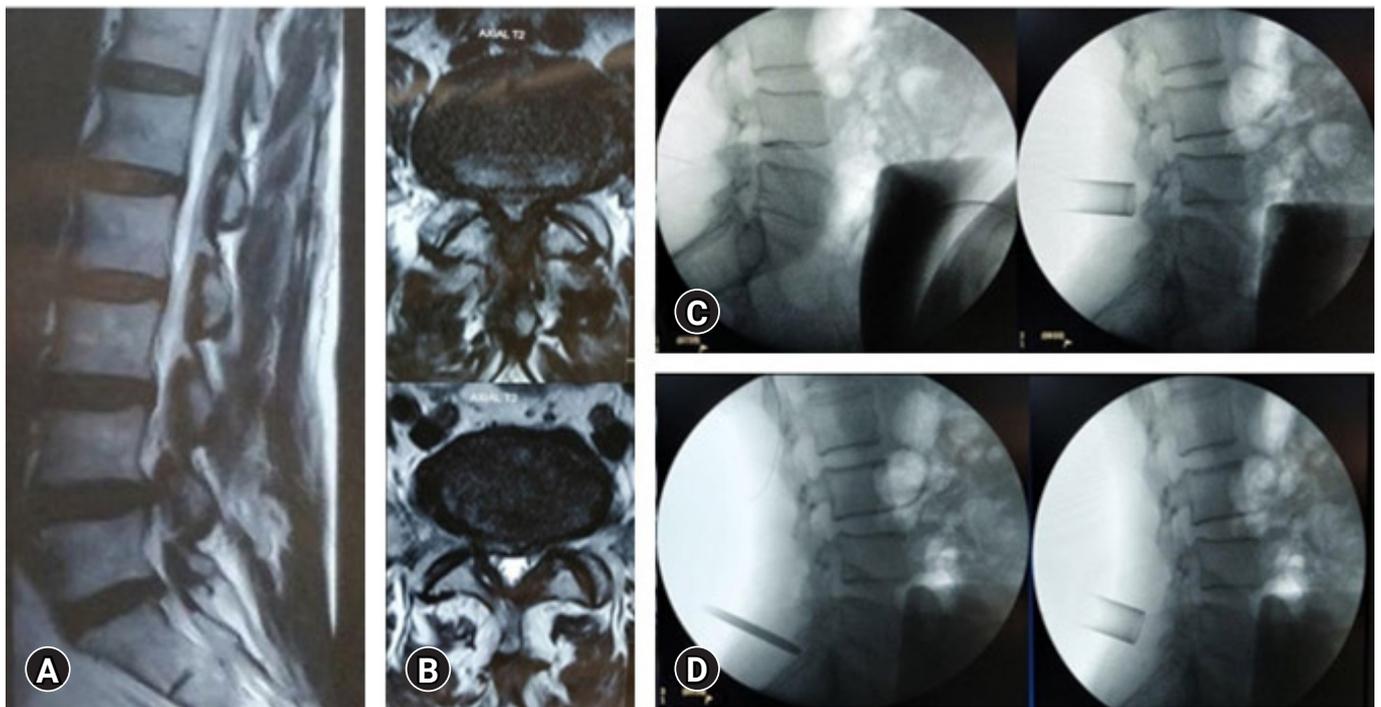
A 59-year-old male (case 12) with L4-5 stenosis and L5-S1 lateral recess stenosis as seen in the sagittal (A) and axial (B) MRI images. The fluoroscopy images demonstrate docking of the tubes at L4-L5 (C) and L5-S1 (D) levels through a single incision.
